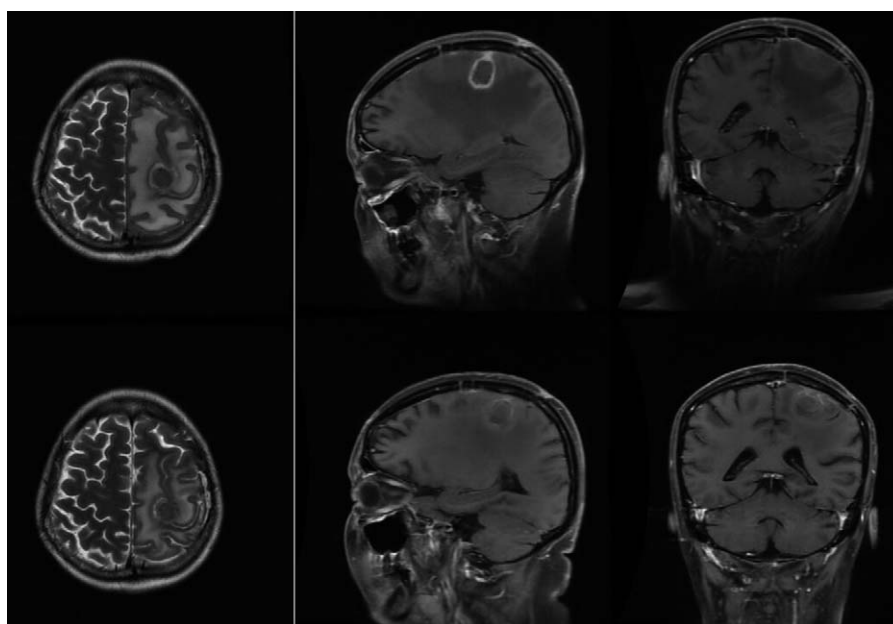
The 6 pictures are the cranial MRI images before and after apatinib treatment of case 2 who do not get benefits from conventional therapy of mannitol and dexamethasone for dehydration. Compared with the MRI images before apatinib treatment, horizontal plane of T2-weighted MR after apatinib treatment revealed that the large perilesional edema in the left frontal and parietal shrank obviously. In the vertical plane and coronal plane of T1-weighted MR, after apatinib treatment, the perilesional edema in the left parietal and oppression of the surrounding tissue improved, and structure of the left side of the third ventricle could be observed again.
